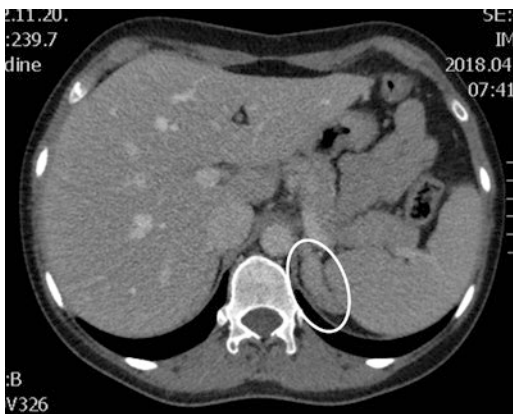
Enlarged hyperplastic left adrenal on the CT of the patient. The right adrenal is normal
